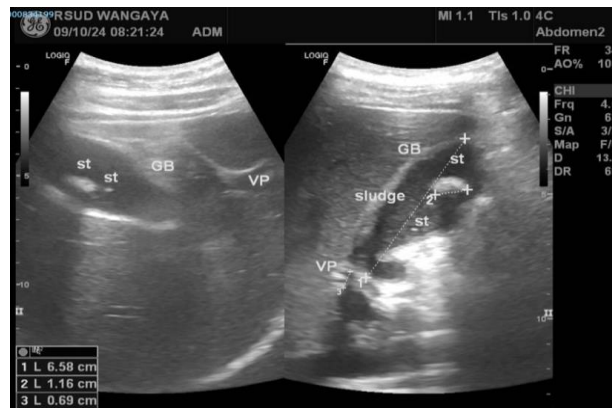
Ultrasonography of the patient's gallbladder.
